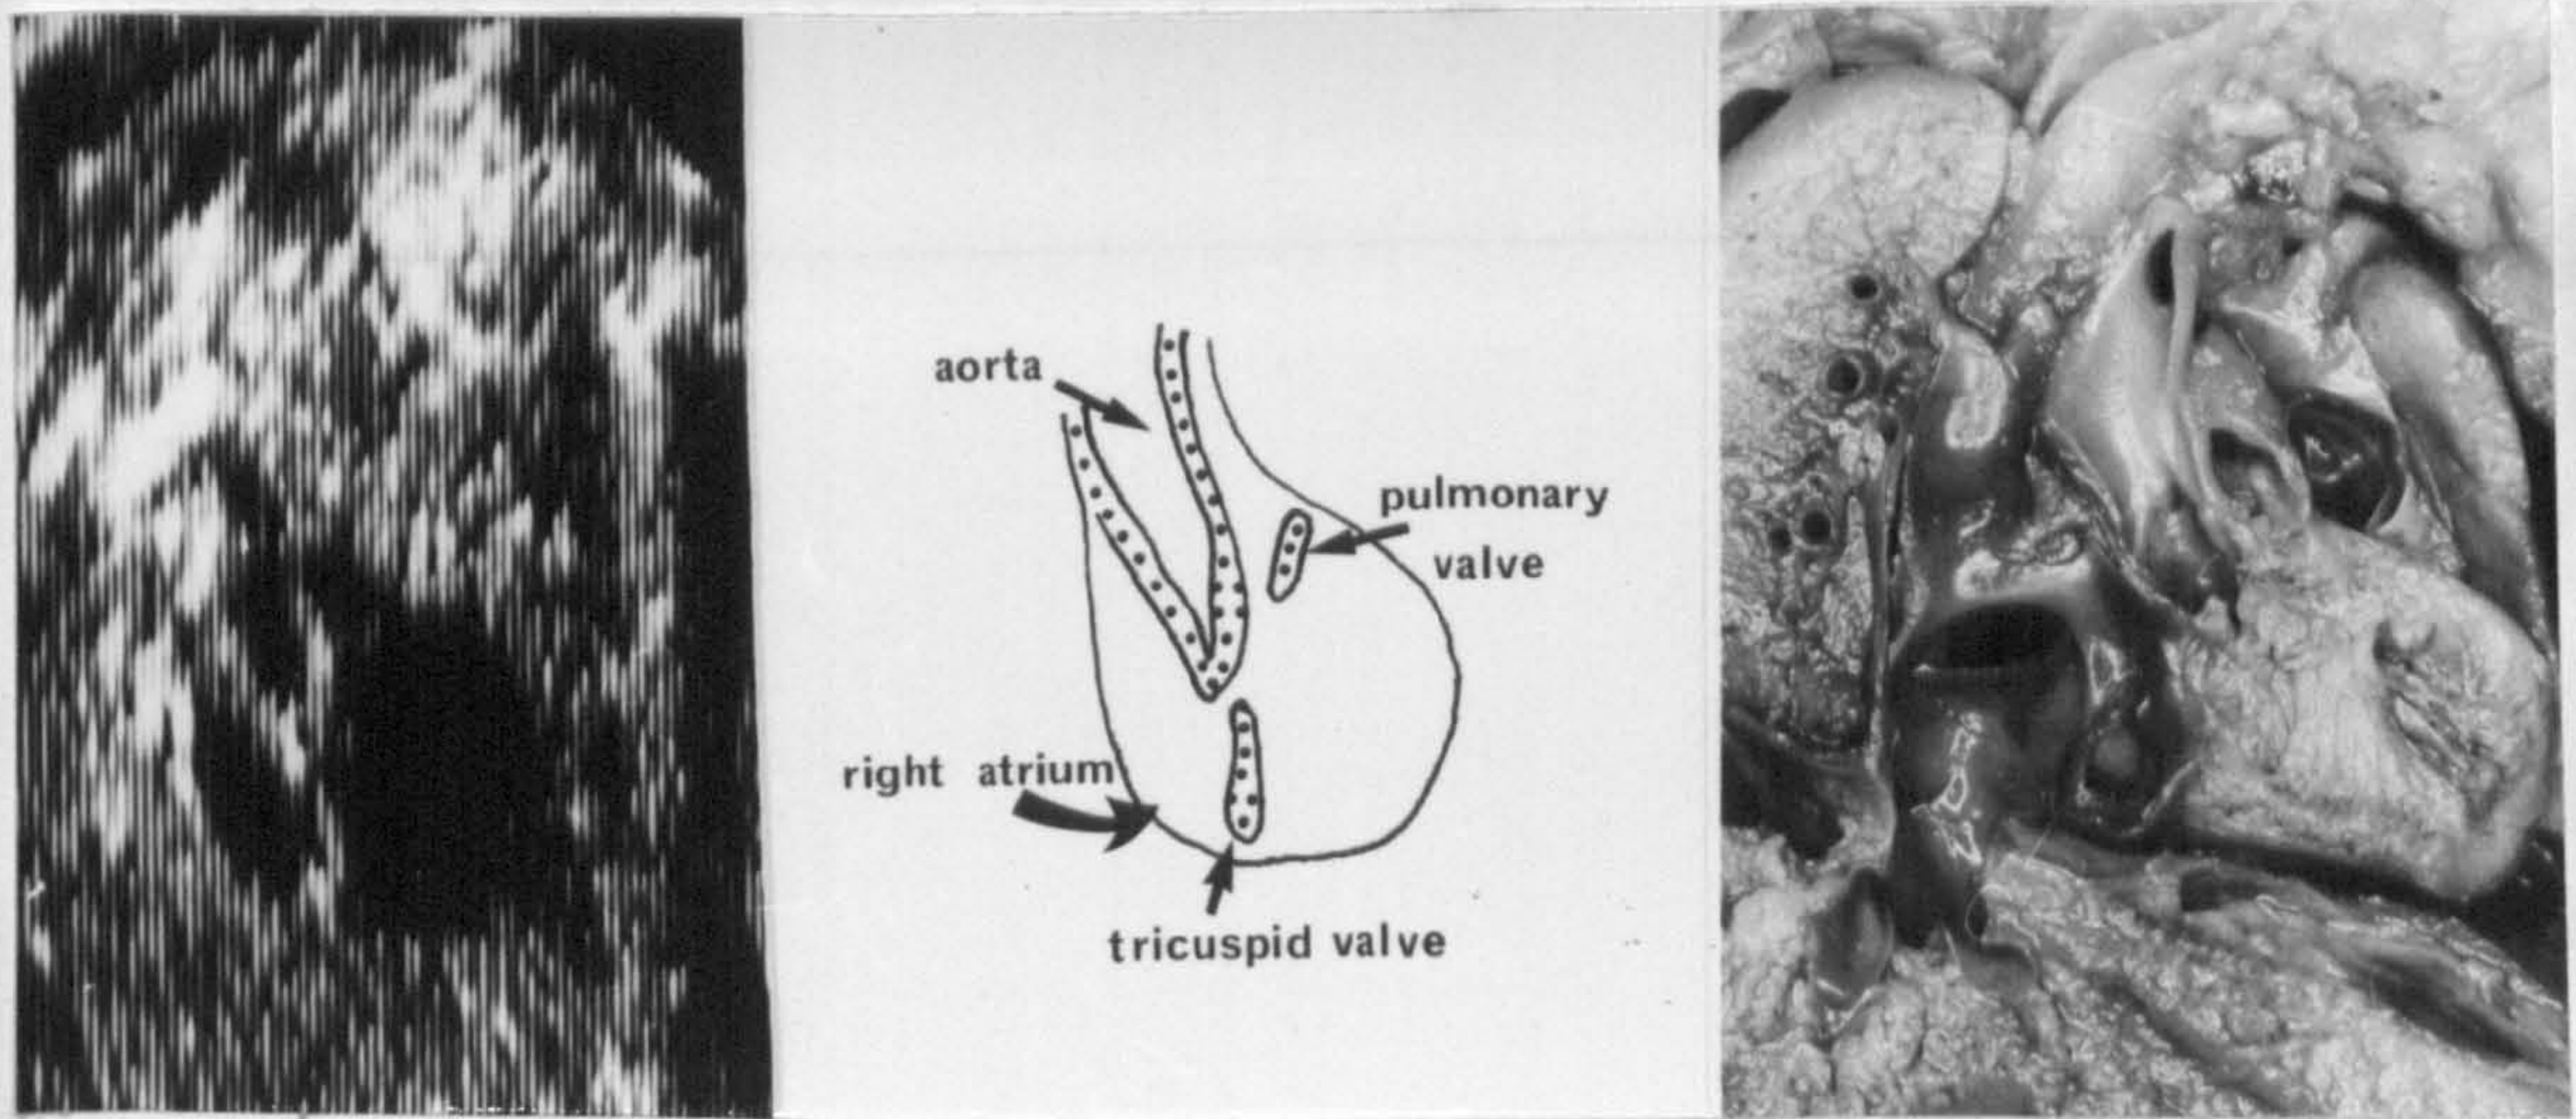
The tricuspid pulmonary plane displayed echocardiographically and anatomically. The right atrium, tricuspid valve, pulmonary outflow tract and pulmonary valve can be seen. The aorta sweeps out of the centre of this section from the left ventricle which lies posteriorly.
